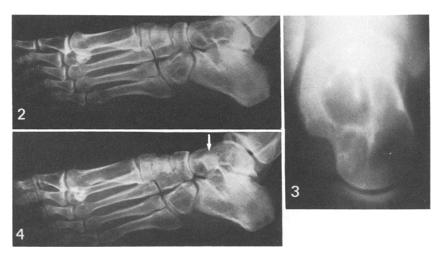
Roentgenogram of the right foot showing radiolucent cystic lesions in the tarsal, metatarsal and phalangeal bones
